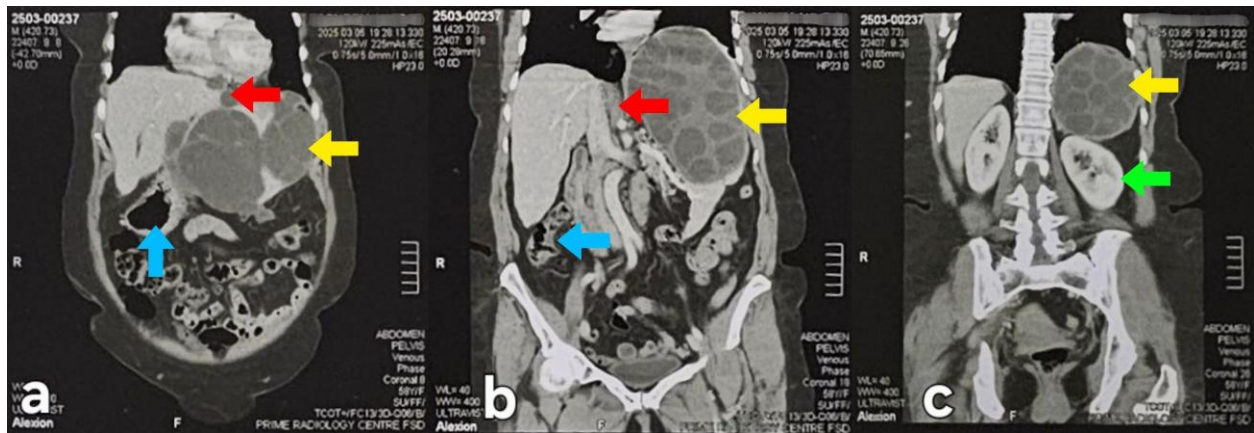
Coronal contrast-enhanced CT images. (a) The cyst (yellow arrow) shows a multivesicular daughter-cyst pattern, with visible displacement of the stomach (blue arrow). The left hepatic lobe (red arrow) is displaced medially. (b) The left hepatic lobe appears thinned and vertically molded against the cyst (red arrow), suggesting pressure-related volume loss. The splenic cystic lesion remains prominent (yellow arrow), with associated medial displacement of the stomach (blue arrow). (c) Inferior displacement of the left kidney (green arrow) due to the hydatid cyst (yellow arrow) is seen, while the right kidney remains in a normal anatomical position.
